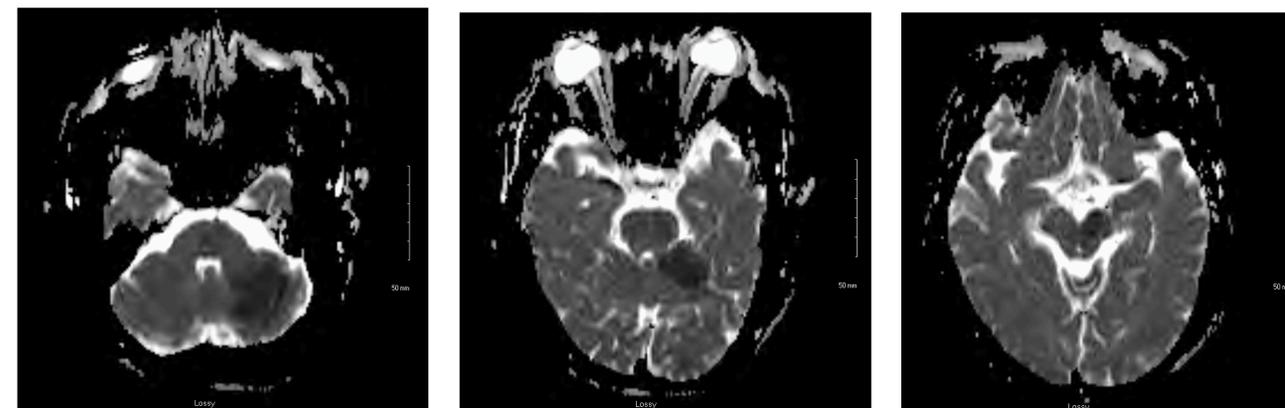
MRI brain w/o contrast showing acute infarcts within midbrain, pons, posterior left occipital lobe and both cerebellar hemispheres.
